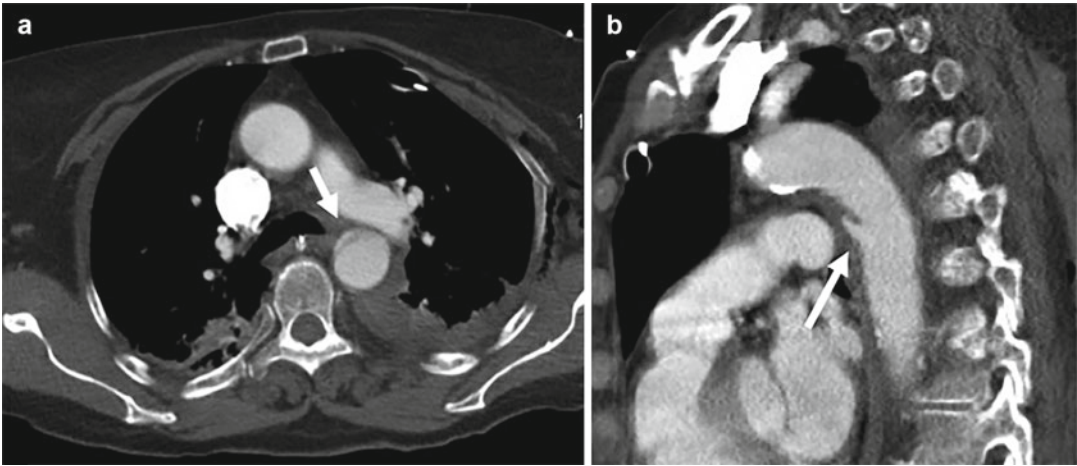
Long traumatic intramural haematoma (*white arrows*) of the descending thoracic on axial (a) and coronal (b) CTA. Concomitant thoracic vertebral body fracture and dislocation (*black arrow*)
